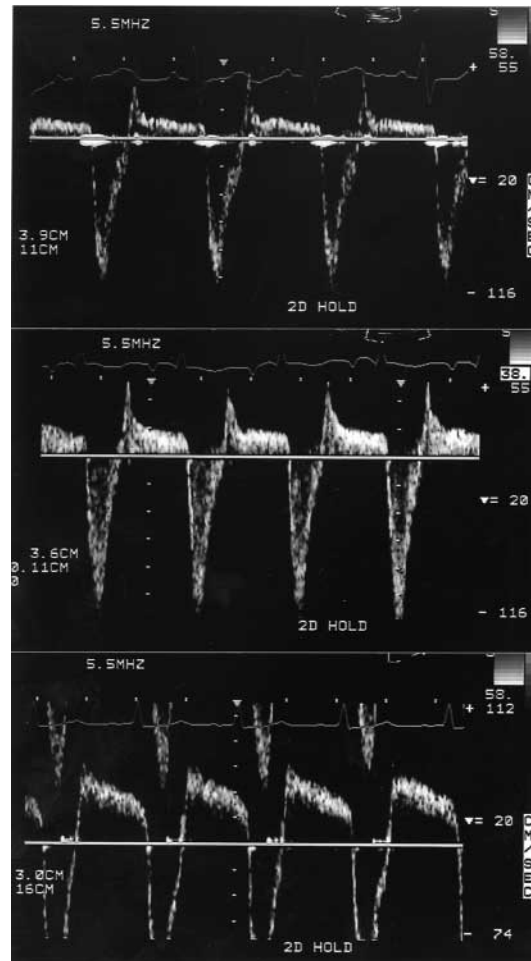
Doppler spectral display of the waveforms generated when sampling in the descending aorta after first-stage palliation for HLHS. Flow below the baseline represents antegrade flow in systole; flow above the baseline represents retrograde flow in diastole. The DFR ratio is calculated by measuring the velocity-time integral of retrograde and antegrade flow done by using planimetrics for the area under each curve and dividing the former by the latter. Three patients are exhibited. The *top panel* demonstrates a small amount of flow reversal, indicating low Qp/Qs; the *middle panel* demonstrates a moderate amount of flow reversal; and the *lower panel* demonstrates a large degree of reversal, indicating high Qp/Qs.
